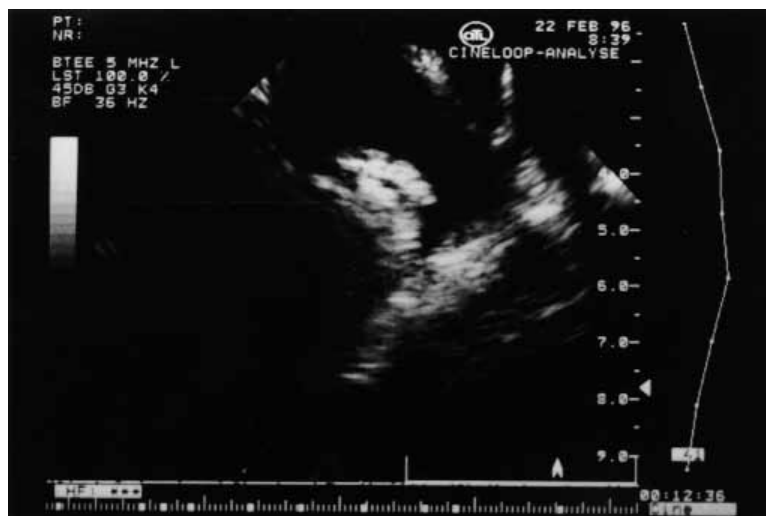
Transesophageal echocardiography demonstrates a mass in the left atrium. The mass appeared to be mobile and seemed to arise from the septum in close proximity to the posterior leaflet of the mitral valve.
